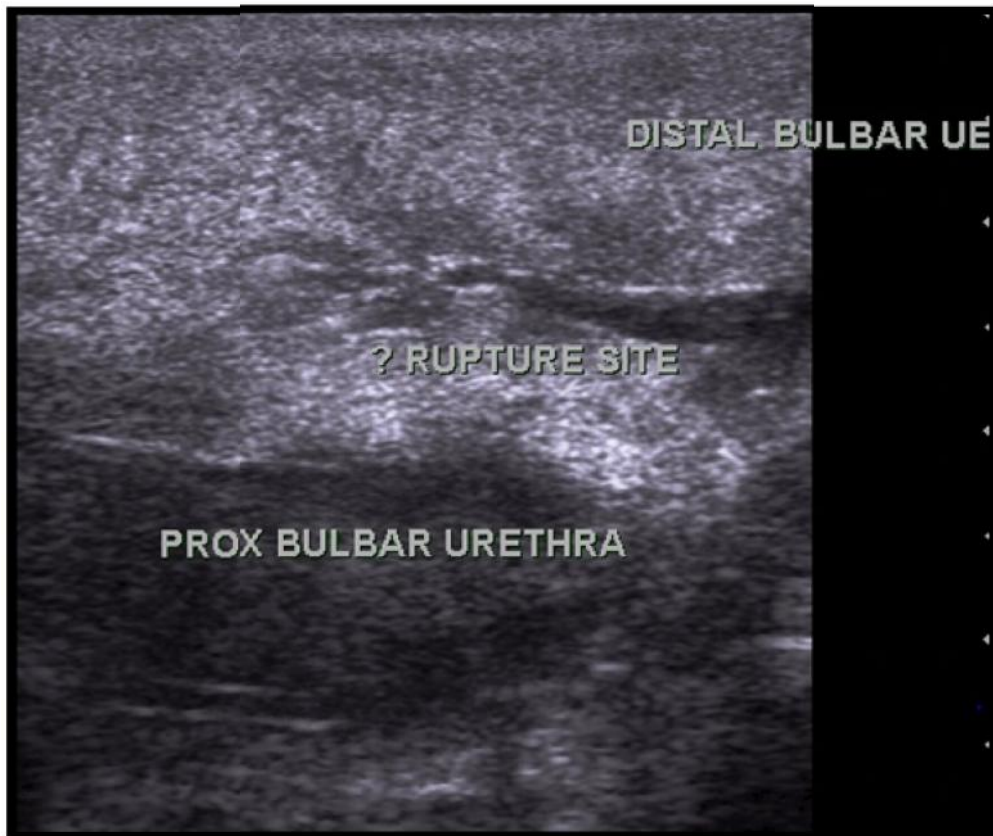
Sonographic imaging of rupture of bulbar urethra.
